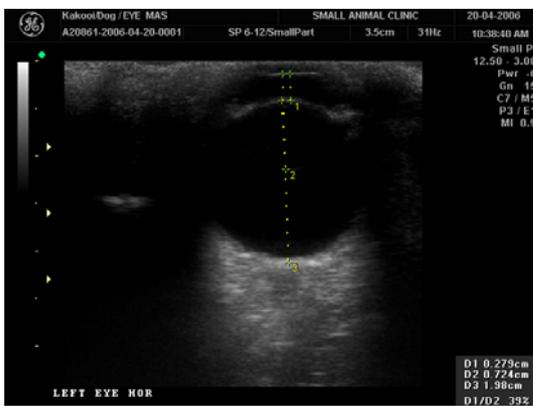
Ultrasonogram of the left eye. Showing diameter of the anterior chamber (D_1), diameter of lens (D_2) and diameter of globe (D_3). An echogenic area in the anterior chamber is seen
